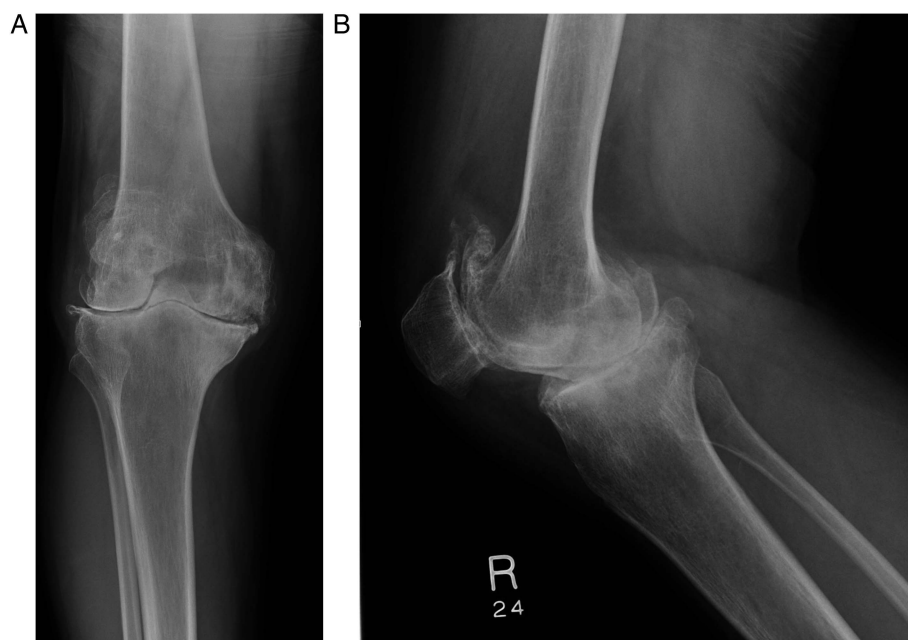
(A) Anteroposterior (AP) and (B) lateral radiographs of a patient's right knee. These show severe tricompartmental osteoarthritis, broadening of the intercondylar notch, squaring of the inferior patellar margin, bulbous femoral condyles and flattened condylar surfaces.
